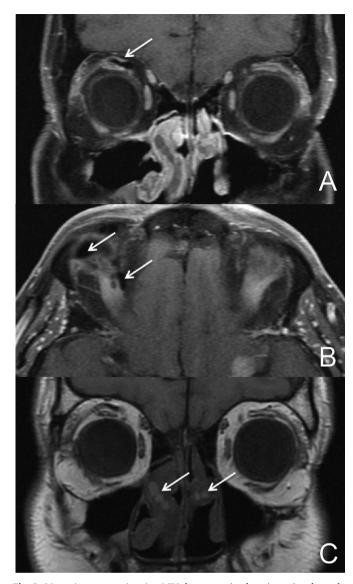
Magnetic resonance imaging.* MRI demonstrating hypointensity above the right levator palpebrae superioris in a T1, post-contrast, coronal image with fat saturation (a), hypointensities in the right orbit along the levator palpebrae superioris in a T1, post-contrast, axial image with fat saturation (b), and mild hyperintensities in the right middle meatus in a T1, non-contrast, coronal image (c), consistent with silicone infiltration.
